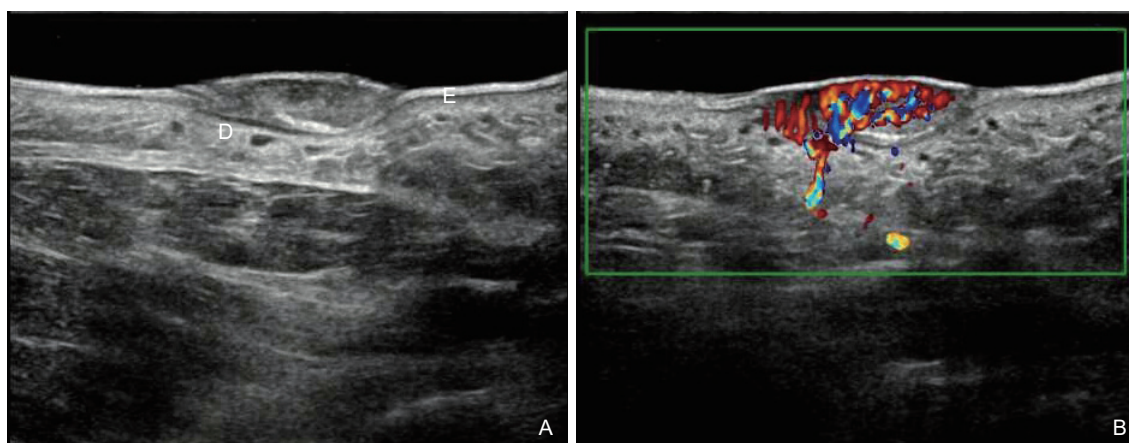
A eccrine poroma in epidermis (E). (A) Ultrasound revealed a 20×6 mm solid and well-defined hypoechoic nodule in epidermis (E); (B) Color Doppler showed cord-like blood flow signals.
